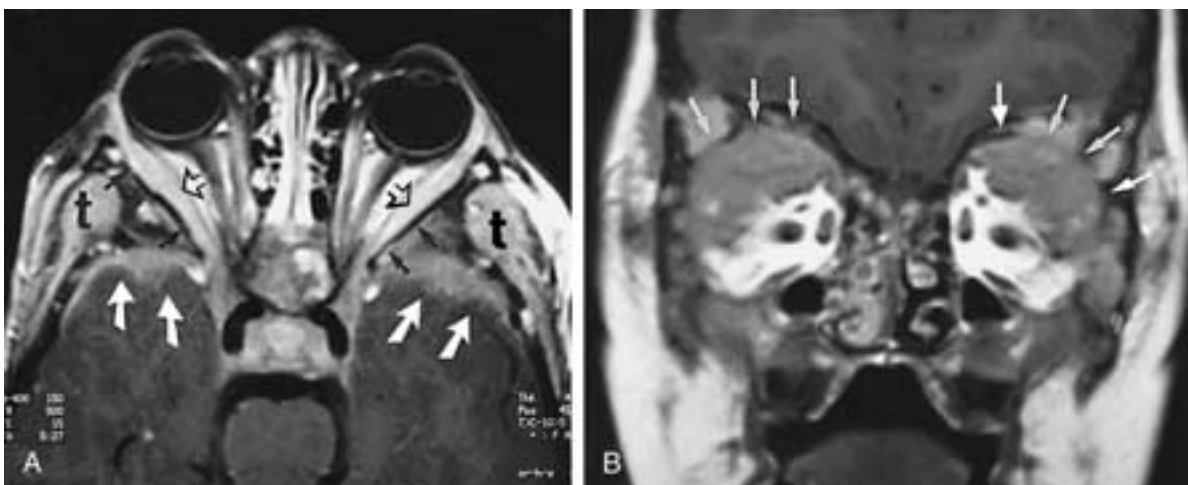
JXG. A, Enhanced axial T1-weighted MR image shows an enhanced soft-tissue infiltrative process involving the lateral orbital walls (*open arrows*), epidural space (*white arrows*), and temporal fossa (*t*). B, Enhanced coronal T1-weighted MR image shows marked soft-tissue infiltration of both orbits (*arrows*), as well as involvement of the frontal bone on both sides. (From Hidayat AA et al. Langerhans' cell histiocytosis and juvenile granuloma of the orbit. *Radiol Clin North Am* 1998;36:1229–1240.)
